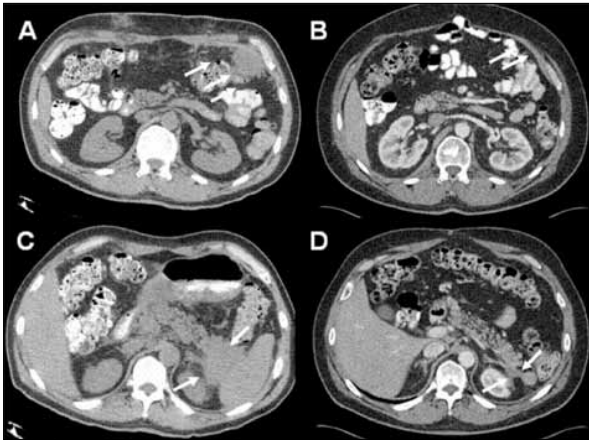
Axial computed tomography (CT) scan images demonstrating response to chemotherapy. Panels A and C are at baseline, and panels B and D are after chemotherapy. The upper panel shows regression of a large omental mass. The lower panel shows regression of the mass in the tail of the pancreas.
